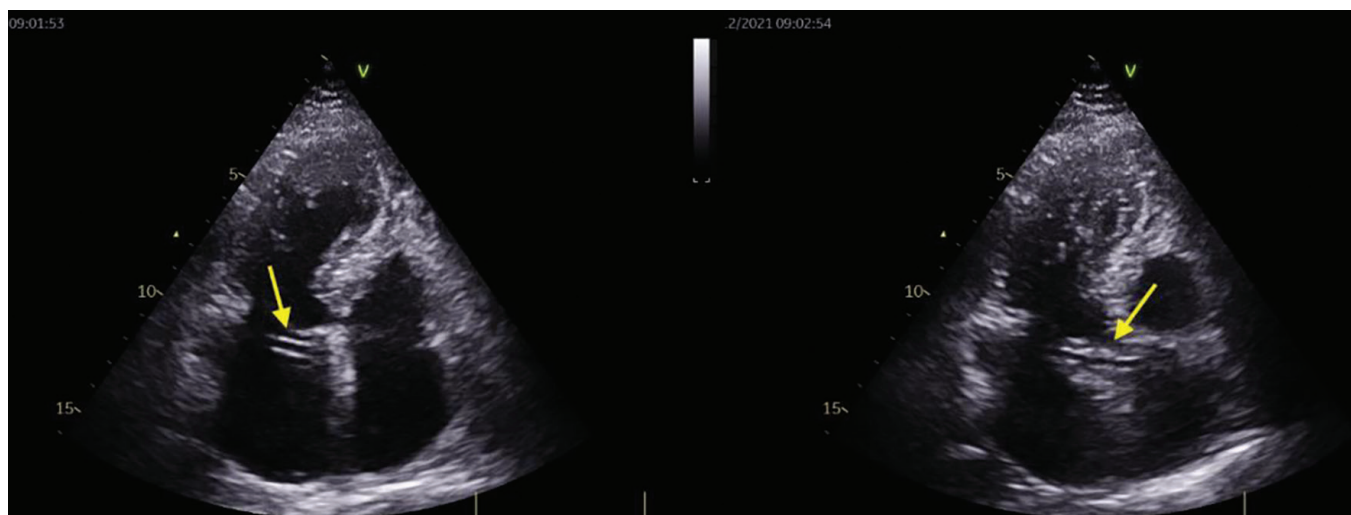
Transthoracic echocardiographic demonstrating the retro-aortic anomalous coronary artery sign (yellow arrow) in a typical apical four-chamber view
